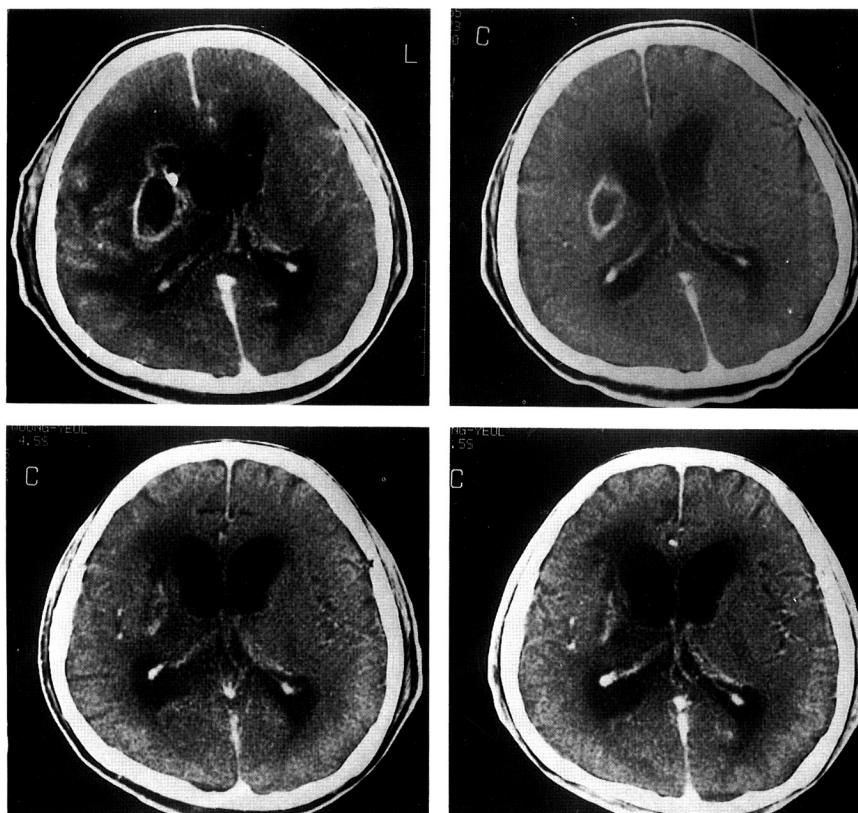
Serial enhanced CT scans after aspiration. Upper left : after aspiration and external ventricular drainage. Upper right : 36 days after aspiration. Lower left : three months after aspiration. Lower right : 6 months after aspiration.
